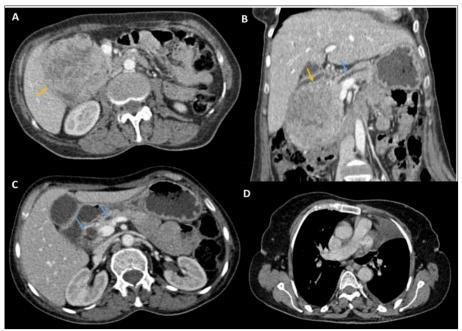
Thoraco-abdominal CT scan images in axial (A, C, D) and coronal reconstruction (B) reveal a large, well-defined, oval mass in the head of the pancreas (yellow arrow) with lobulated contours and heterogeneous density containing liquid areas, which enhances after contrast injection. This mass is responsable of a double-duct dilation (blue arrow) and atrophy of the corporeo-caudal pancreatic parenchyma
